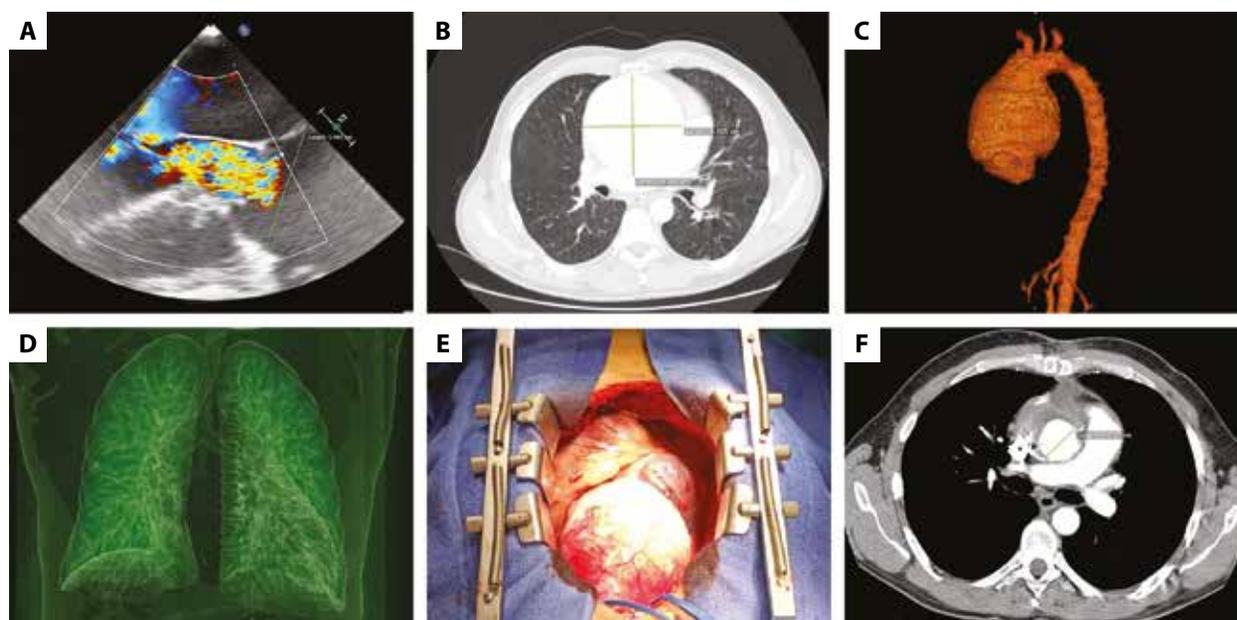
A. Preoperative transesophageal echocardiography showing severe aortic valve regurgitation. B. Preoperative computed tomography angiography showing a giant ascending aorta aneurysm. C. Preoperative computed tomography angiography 3D reconstruction showing the aneurysm involving the aortic root, ascending aorta and proximal segment of the aortic arch. D. Preoperative computed tomography 3D reconstruction of the pulmonary matrix. E. Intraoperative image of the aortic aneurysm. F. Follow-up computed tomography angiography 2 months post-surgery
